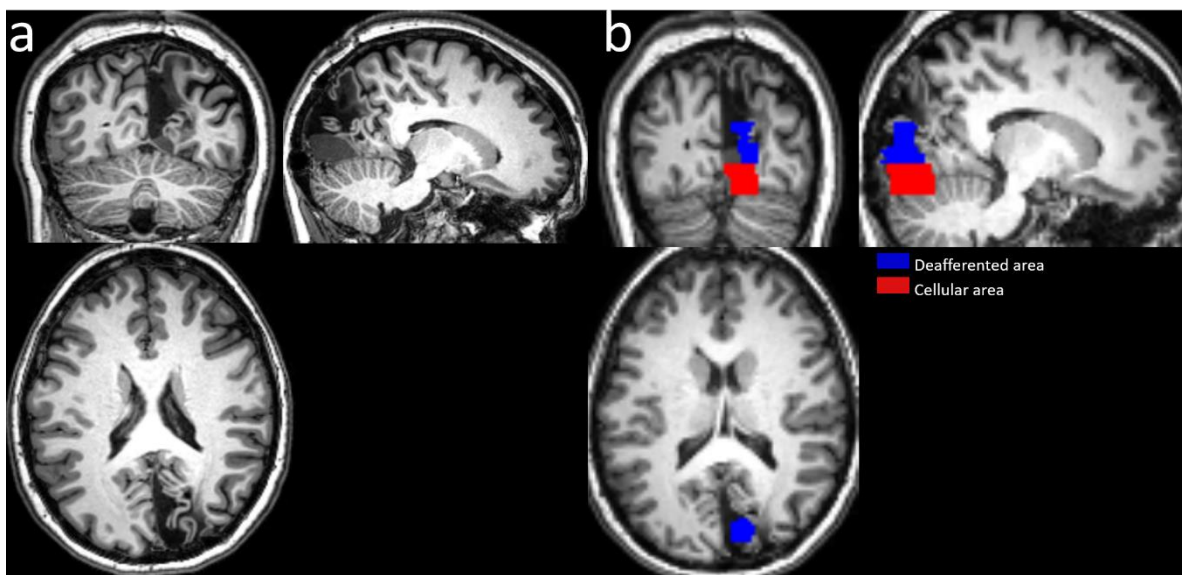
a. MRI sections showing the occipital cortex lesion. b. DTI showing in blue the deafferented area and in red the area presenting a resurgence of the tumor.
